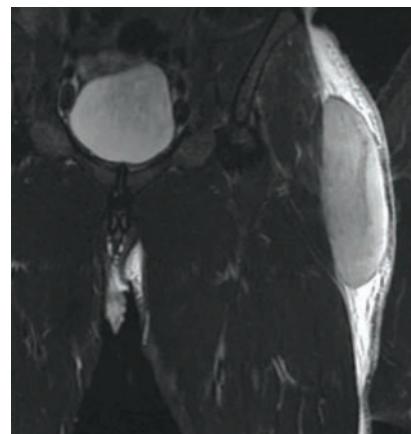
Coronal short tau inversion recovery magnetic resonance imaging of the left thigh demonstrates an extrafascial fluid collection.
